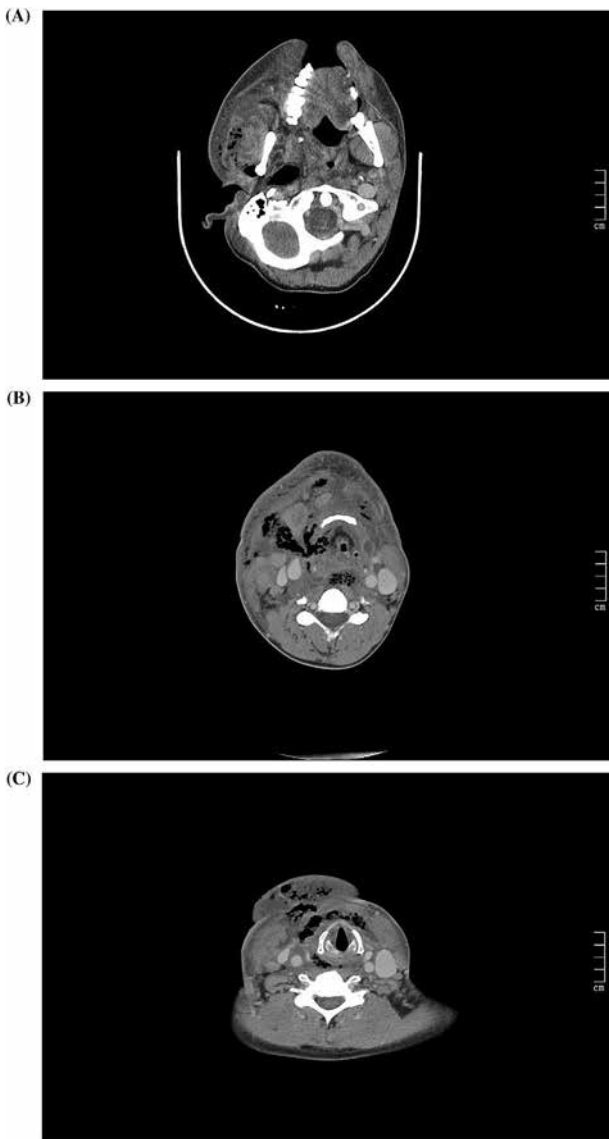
A–C: CT images of transverse sections through the floor of the mouth into the larynx.
